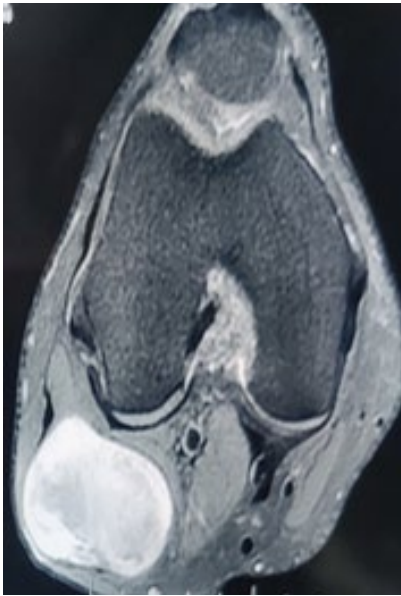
MRI Rt Knee Axial Plane
